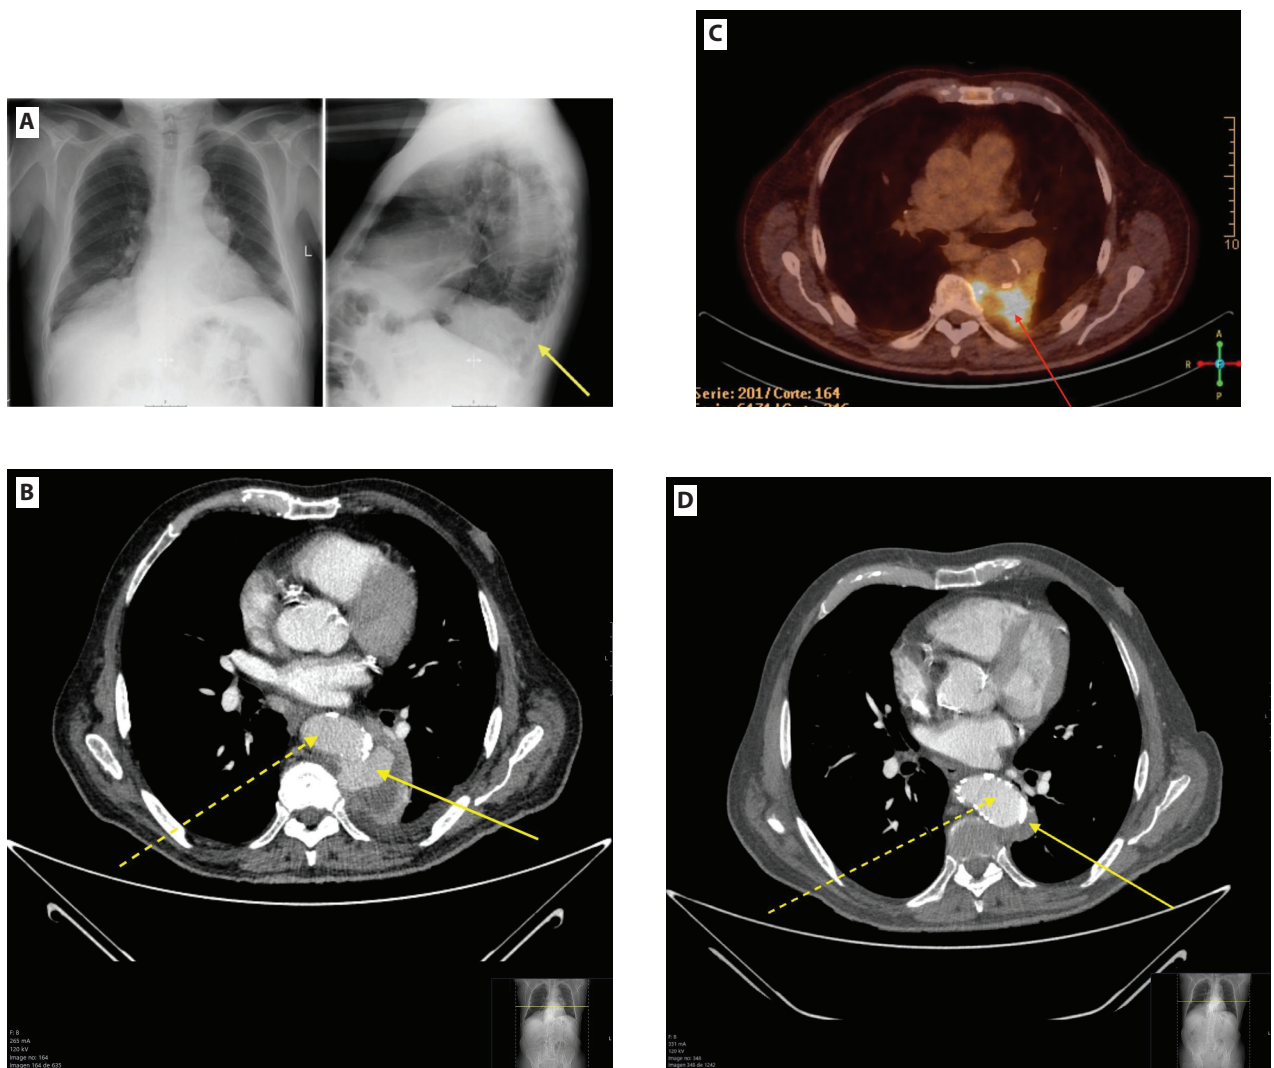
A) Posteroanterior (left) and lateral (right) chest X-ray upon admission showed retrohilar opacity erasing the aortic contour (arrow); B) CT scan of the chest (mediastinal window) demonstrates a posterior descending aortic aneurysm with contained rupture (solid arrow) and 'draped aorta' sign (dashed arrow). Peripheral thrombotic-necrotic material (without enhancement) is noted within the aneurysm sac; C) PET-CT image of the chest showing an hypermetabolic focus around the aortic aneurysm is observed (arrow). D) CT scan of the chest (mediastinal window) showing the aortic stent delineating the normal aortic lumen (dashed arrow). The excluded aneurysm has retracted and is now completely thrombosed and of diminished size (solid arrow).
